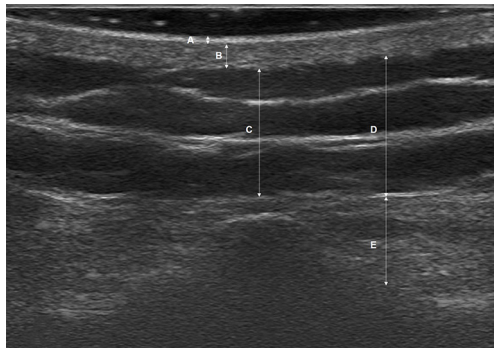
Ultrasonographic manifestations and thickness measurement of each skin layer. (A) Epidermis. (B) Dermis. (C) Median spinal fat layer. (D) Paraspinal fat layer. (E) Paraspinal muscle layer.
